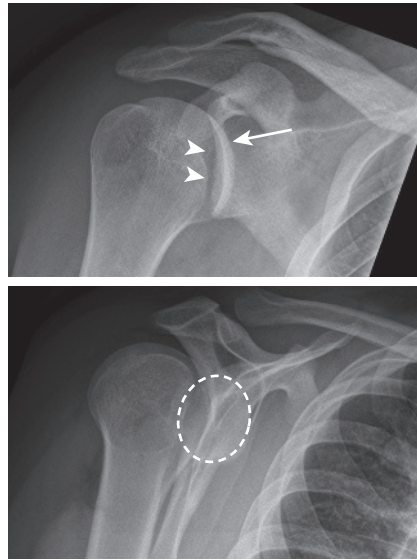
Post Dislocation of the Right Shoulder. Antero-posterior (AP) and lateral radiographs demonstrating a posterior dislocation of the right shoulder. Note that the humeral head overlaps abnormally with the glenoid on the AP projection (*long arrow*). A trough sign is noted, indicating a reverse Hill-Sachs impaction fracture (*arrowheads*). The humeral head is posterior to the glenoid (*dotted circle*) on the lateral projection.
